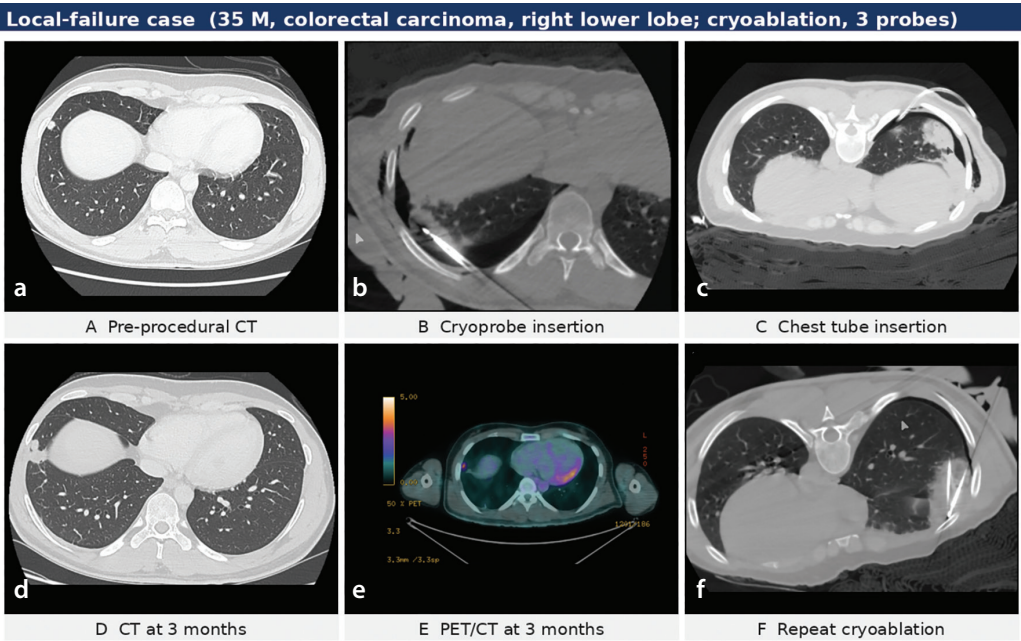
Computed tomography-guided cryoablation (CA) of a right lower lobe metastasis (colorectal carcinoma) with local progression at 3 months, treated by repeat CA; the immediate pneumothorax in (c) was managed with a chest tube. (a) Pre-procedural axial computed tomography (CT) lung window demonstrating a right lower lobe pulmonary metastasis. (b) Intraprocedural CT showing placement of cryoprobes within the target lesion. (c) Immediate post-procedural CT demonstrating a pneumothorax, managed with chest tube insertion. (d) Follow-up contrast-enhanced CT at 3 months demonstrated interval enlargement of the treated lesion, concerning for local tumour progression. (e) FDG PET/CT performed at 3 months showed persistent increased metabolic activity within the treated lesion, confirming residual viable tumour. (f) Repeat CT-guided cryoablation performed for local tumour recurrence. FDG, fluorodeoxyglucose; PET, positron emission tomography.
